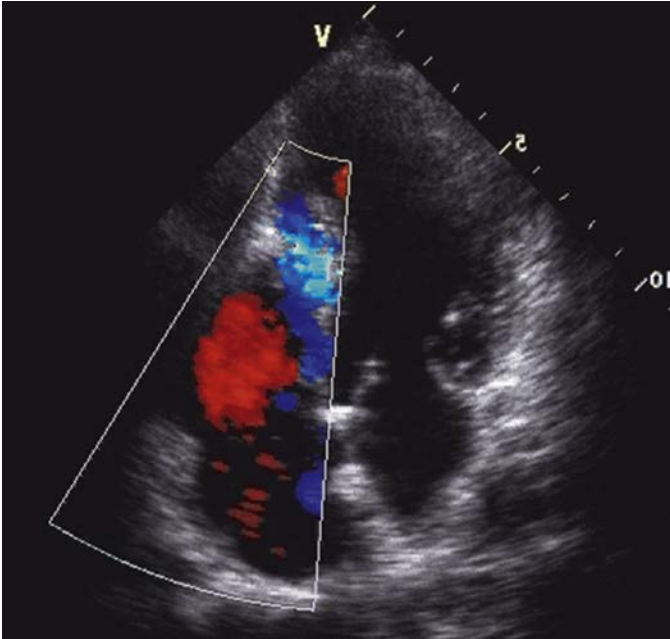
e5 A transthoracic echocardiogram demonstrates the cause of a loud systolic murmur post-myocardial infarction: a ventricular septal rupture with left-to-right shunting. (From Tsang MG, et al: *Echocardiography in acute myocardial infarction*. In Lang RM, et al, editors: ASE's comprehensive echocardiography, 3rd ed. Philadelphia, Saunders, 2016.)
